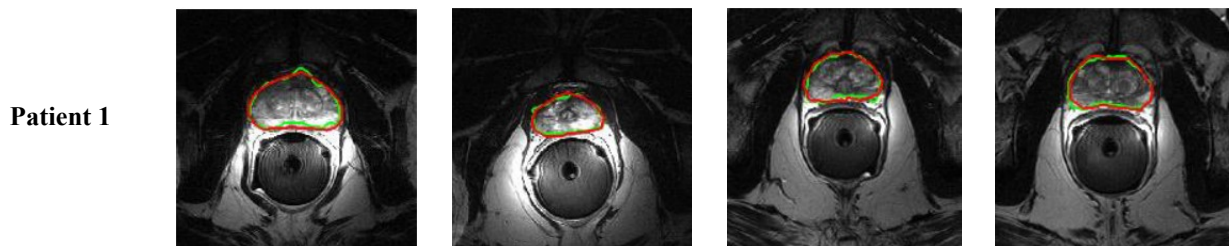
ROI extraction results from T2-w MRI selected slices
